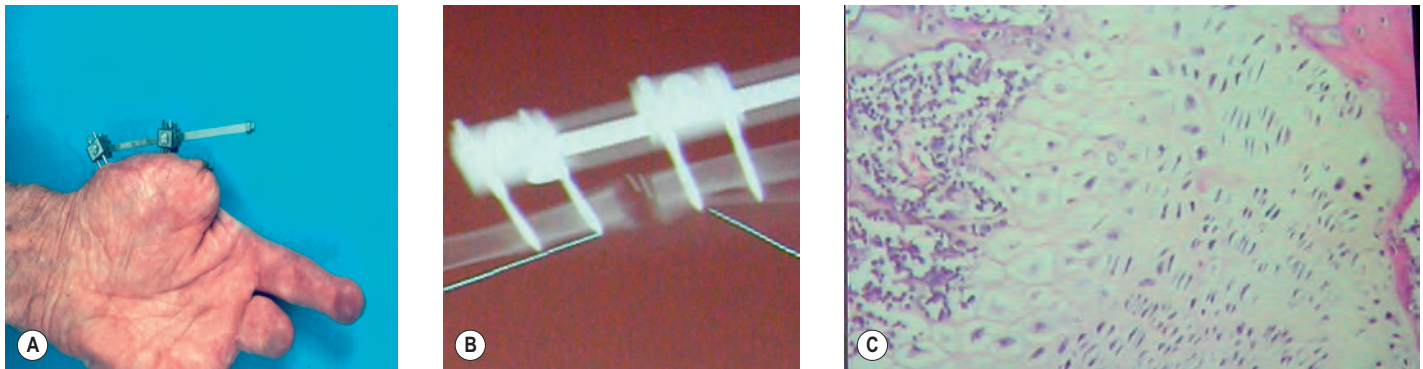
(A) Thumb stump with distraction device. (B) X-ray of bone distraction. (C) New bone filling the gap.
